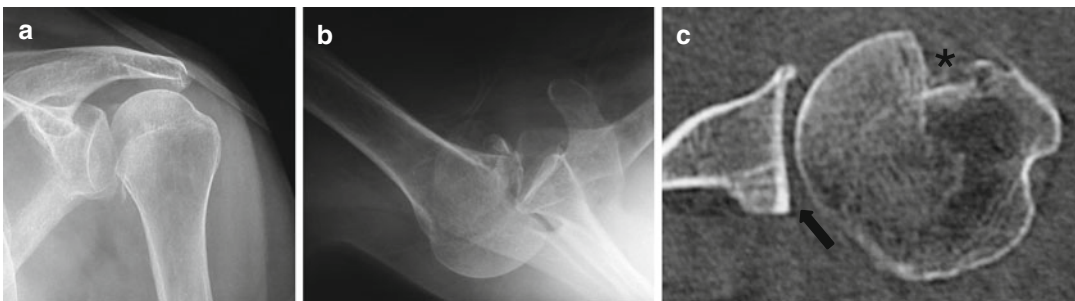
Posterior dislocation (a–c). Anteroposterior (a) and axillary view (b). The CT (c) depicts dislocation sequelae: Reverse Hill-Sachs fracture impaction (*) and glenoid impaction (arrow)
